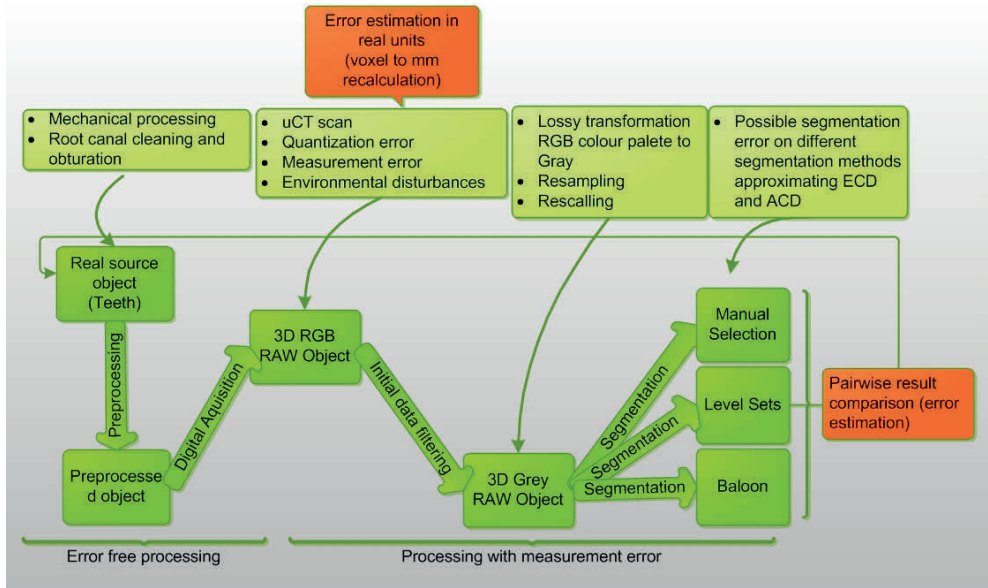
Stages in the acquisition of medical images using  $\mu$ -CT in terms of estimating measurement errors
